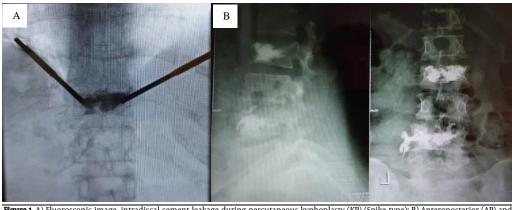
A) Fluoroscopic image, intradiscal cement leakage during percutaneous kyphoplasty (KP) (Spike type); B) Anteroposterior (AP) and lateral lumbar X-ray showing Spike-type intradiscal cement leakage in another patient
